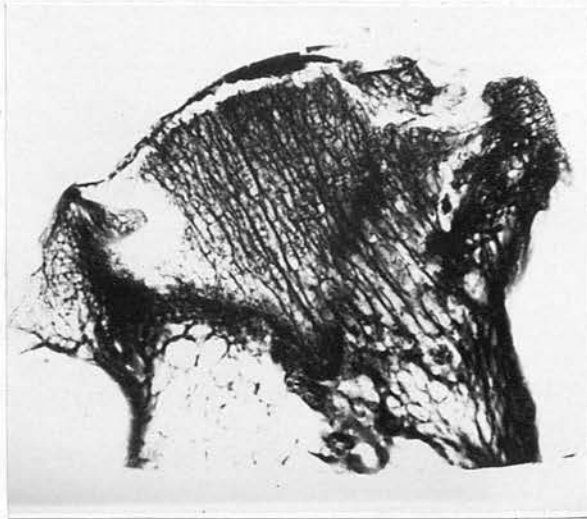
(a) - Radiograph of bone segment from an excised necrotic femoral head. Zone of reossification appears dense.
